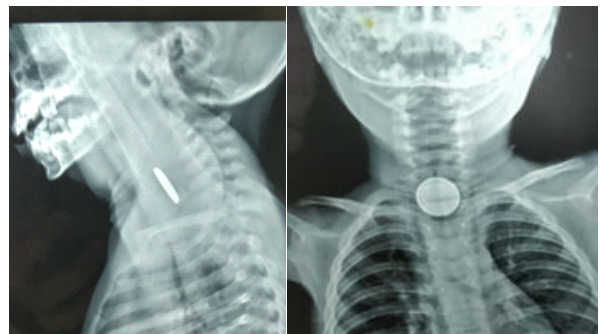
Xray lateral and anteroposterior(AP) view showing a radio-opaque foreign body with double halo sign.
